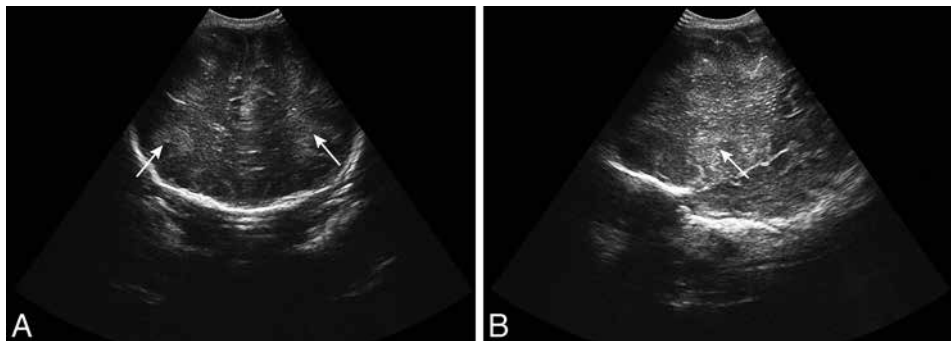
(A) Coronal and (B) parasagittal ultrasound scan in preterm infant, scanned around term equivalent age after a severe hypoxic-ischemic event, showing diffusely increased echogenicity of the parenchyma (arrows) and loss of the normal anatomical landmarks, reflecting severe global brain injury.
